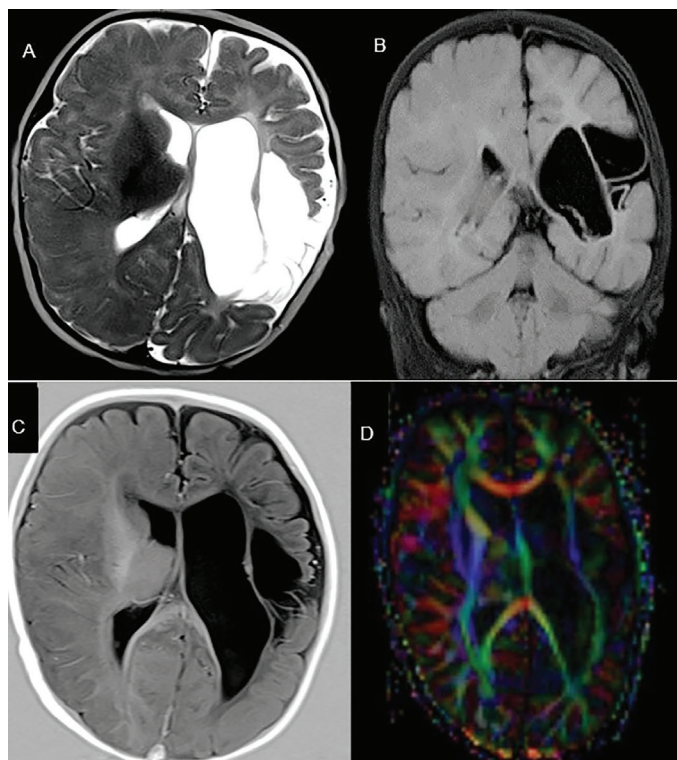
Magnetic resonance imaging of patient number eight. A) Severe periventricular leukomalacia on the left in T2 axial imaging. Retraction and dilatation in the same ventricle. Marked tissue loss in the cortex and white matter. Encephalomalacia area and porencephalic cyst. B) Coronal FLAIR C) T1 axial image. D) Color-code fractional anisotropy map. Red indicates transverse (x-axis), green indicates anterior-posterior (y-axis), and blue indicates superior-inferior (z-axis) direction
